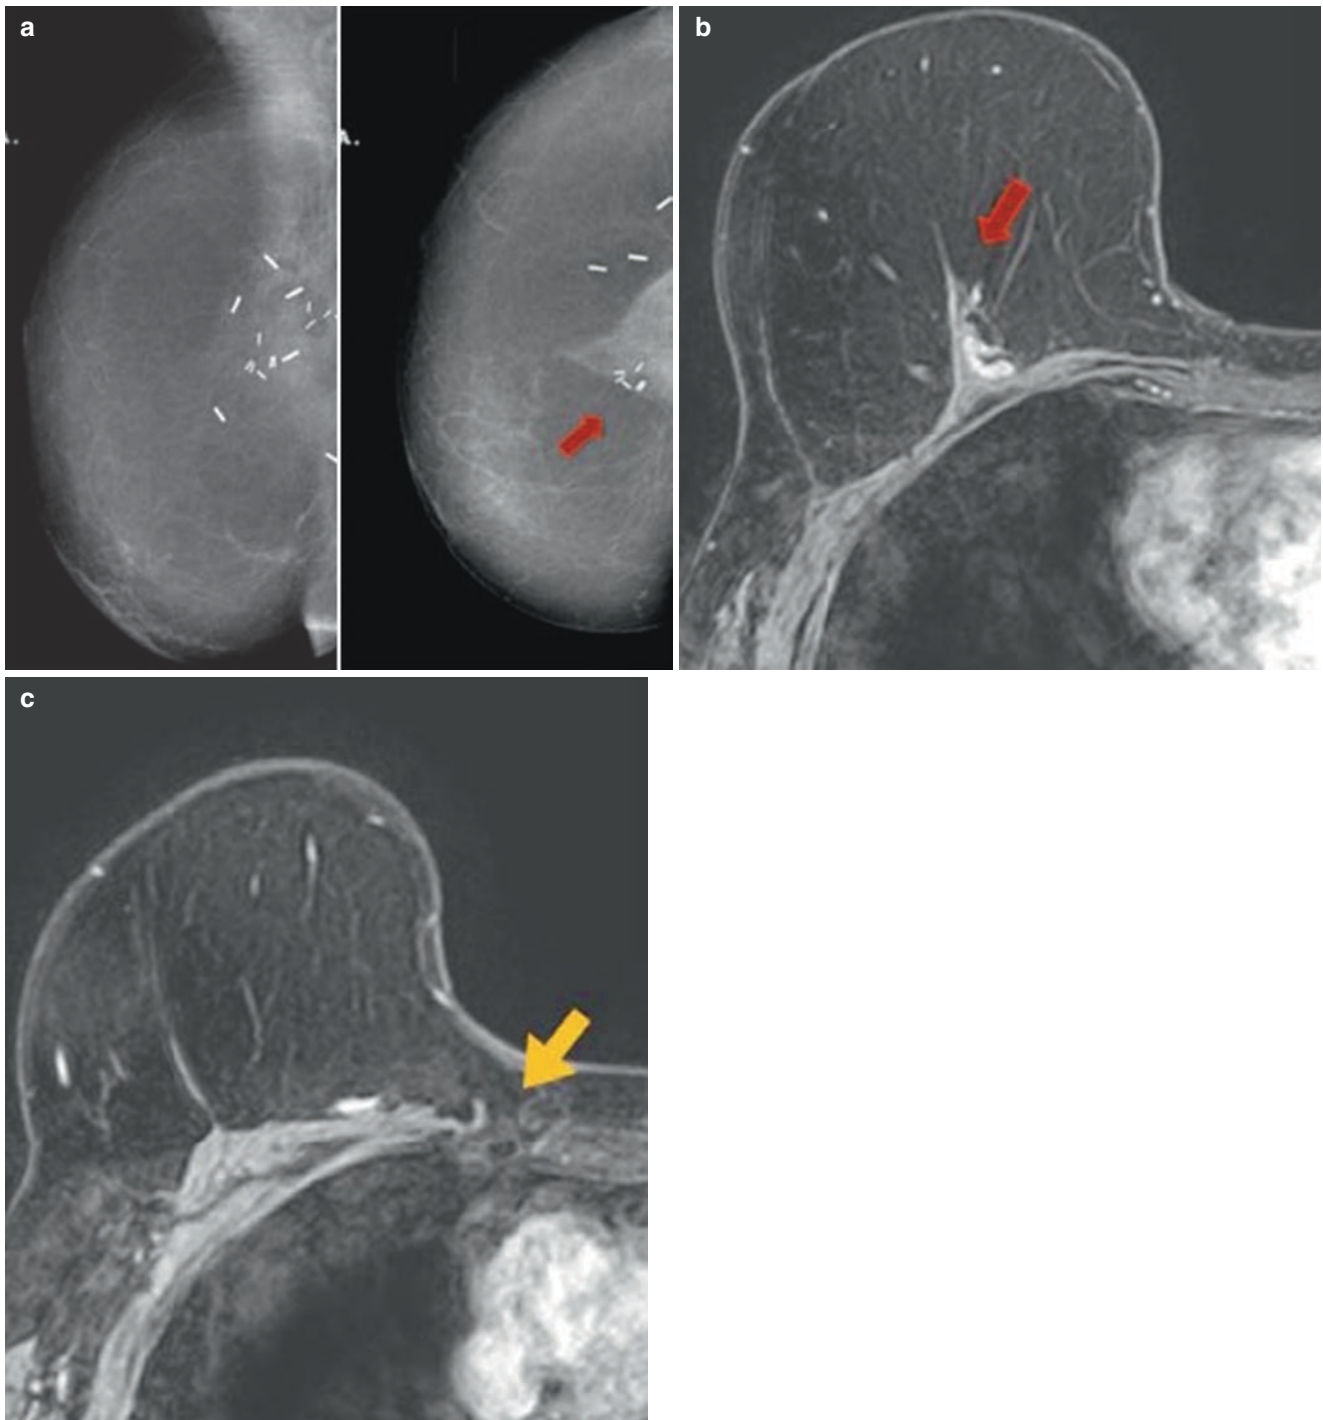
Patient with right mastectomy and autologous reconstruction with free TRAM flap. (a) On mammogram, a muscular density is seen anteriorly to the chest wall and the pectoral muscle (*red arrow*). (b) Breast MRI with dynamic sequences showing the muscle transferred anteriorly to the pectoral muscle, with metallic clips and some
